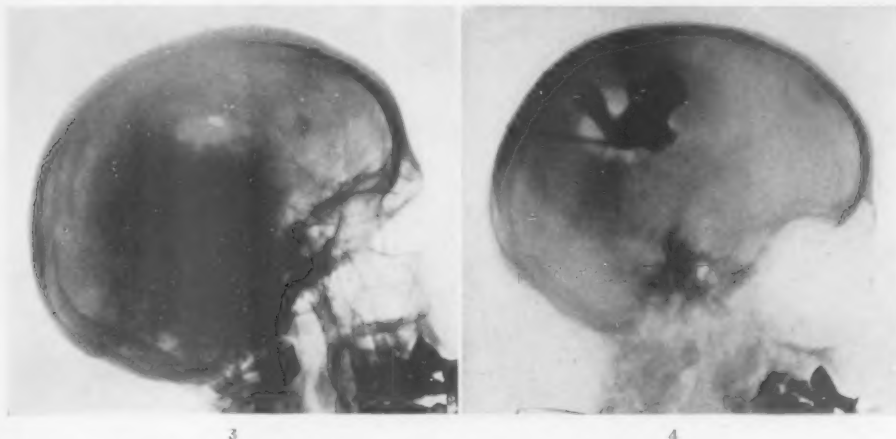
Radiograph after the bone had been removed, exposing extra-dural abscess.
